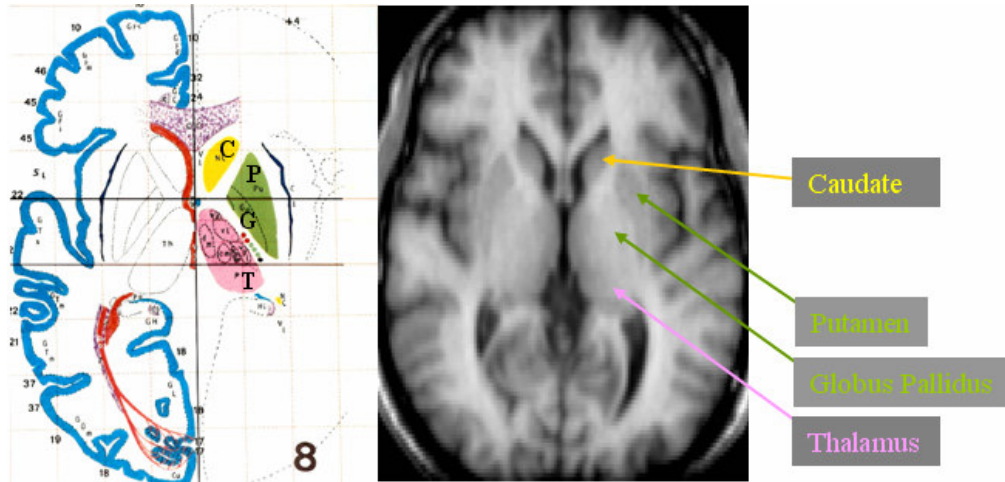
The map of gray matter nuclei in axial view. To the left, an annotated map of deep gray matter internal nuclei reproduced from the Talairach and Tournoux atlas [Talairach and Tournoux 1988]: the caudate (C), putamen (P), globus pallidus (G) and thalamus (T). To the right, deep gray matter internal nuclei as seen in a normal T1 weighted axial MR image with good contrast between WM, GM and CSF.
